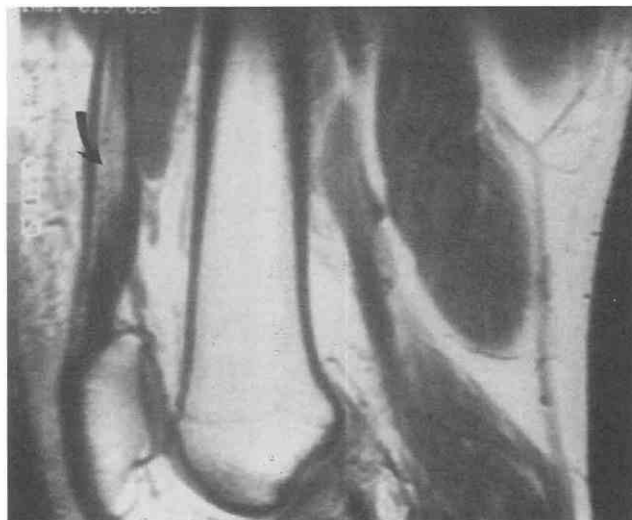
Partial tear of the quadriceps tendon. Sagittal T1-weighted image shows increased signal intensity at the proximal portion of the quadriceps tendon indicative of partial tearing (arrow). The fasciae from the vastus medialis and vastus lateralis are involved with sparing of the fasciae from the rectus femoris and vastus intermedius muscles.
